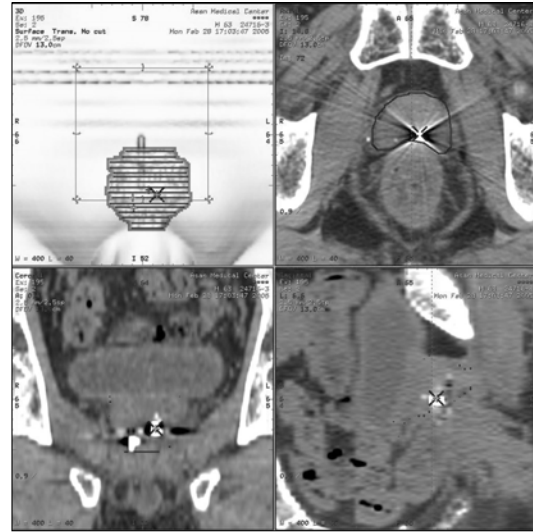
Verification of inter-treatment errors in CT images: position of the implanted markers in prostate and distance between the markers due to their inter-treatment variations were acquired.
